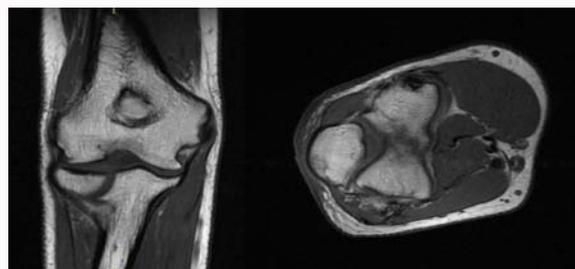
MRI of the left elbow at 22-months later.
